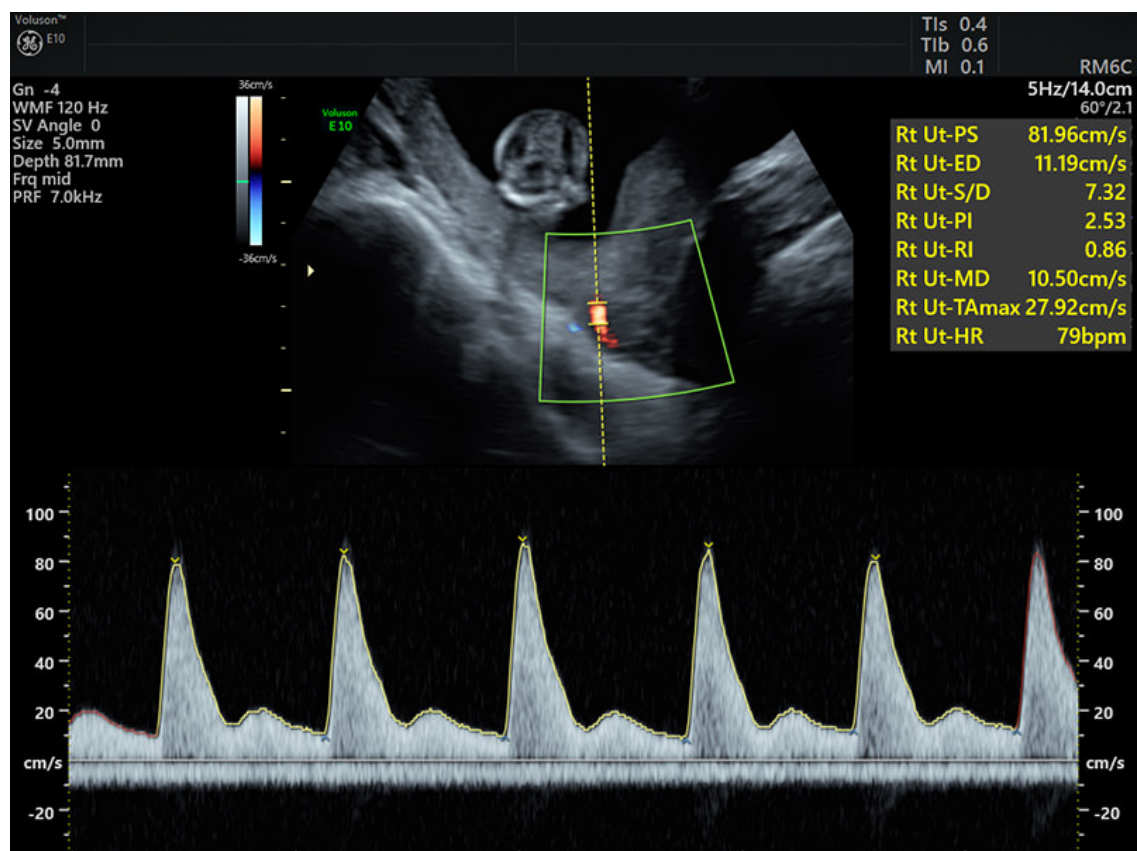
Pre-eclampsia screening by Ultrasound
